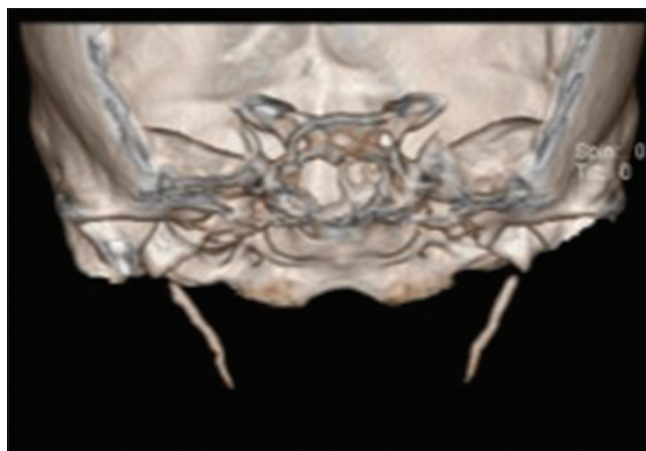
Elongated styloid process. Three-dimensional reconstruction of computed tomography scans showing an elongated styloid process
